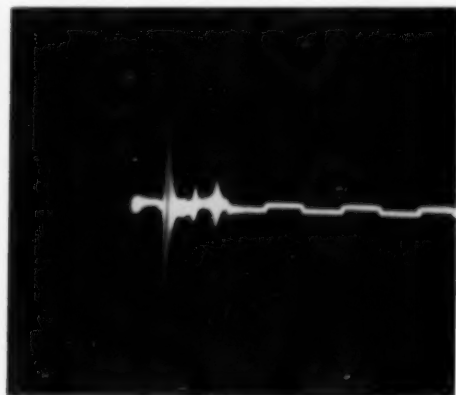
(Mundt and Hughes). Ultrasonic tracing of a child's eye with microphthalmos and retrolental fibroplasia.
